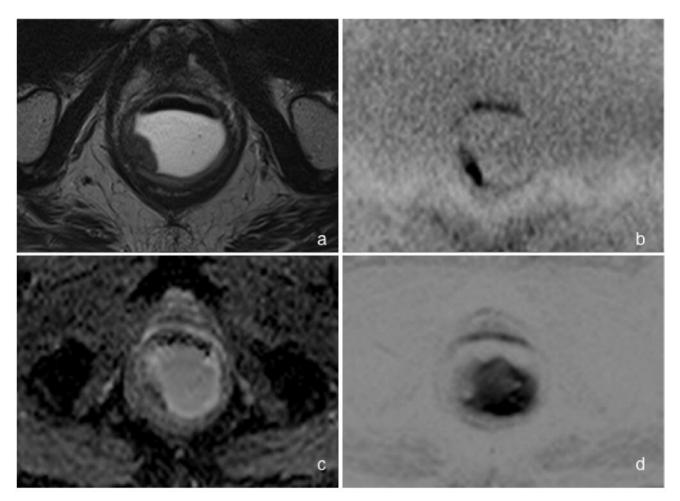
Imaging of a 67-year-old man with rectal cancer after chemoradiation (CRT) (regression grade 1). a: 2D Axial T2-weighted sequence depicts the tumor involving the right side of the rectal wall with soft-tissue signal intensity. b: On b2000 diffusion-weighted imaging (DWI) high signal intensity of tumor is seen, which suggests poor response to CRT and residual tumor. c: Apparent diffusion coefficient map. d: b800 DWI with poor visualization of the tumor (signal of rectal gel is not sufficiently suppressed).
